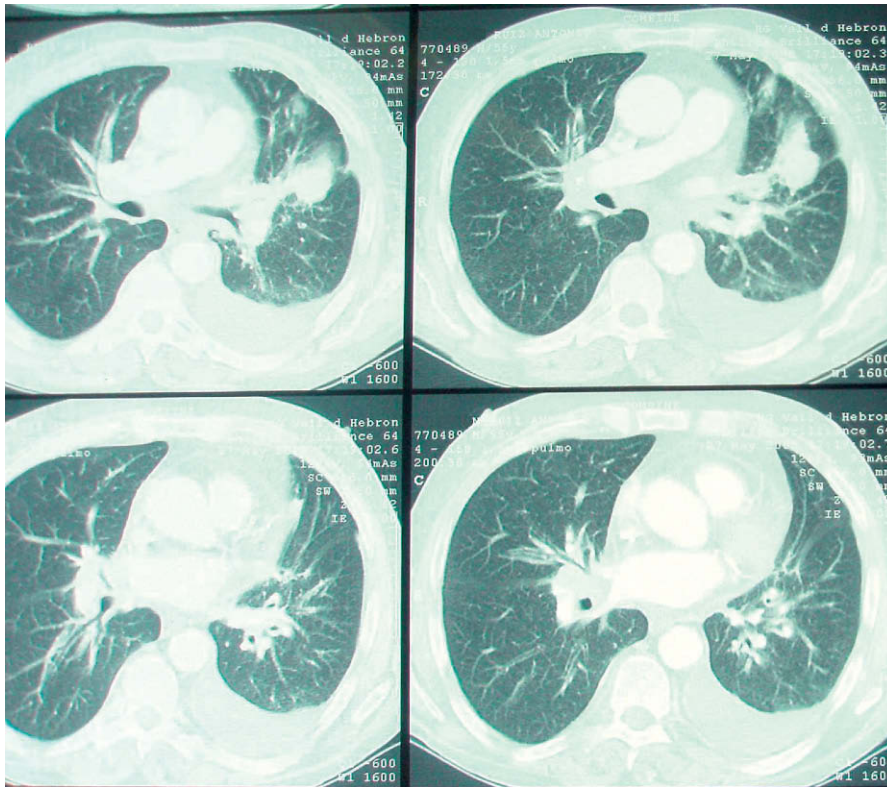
Chest CT (2008): mass of approximately 3 cm in ULL. Peribronchovascular thickening in the ipsilateral pulmonary hilum. Significant mediastinal and contralateral hilar adenopathies. Left-sided pleural effusion with nodular thickening of the left costophrenic sinus.
